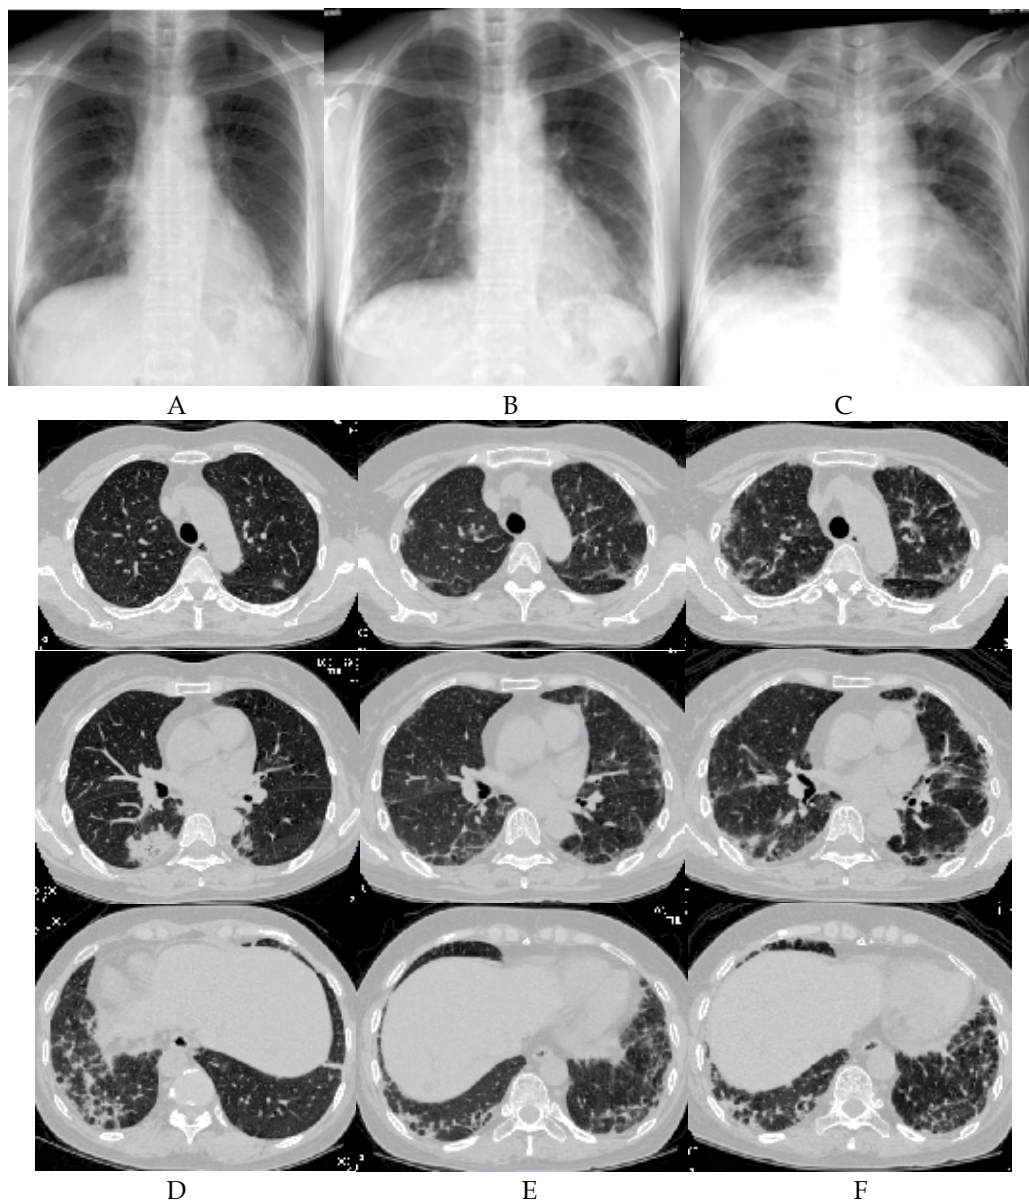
Chest radiographs and computed tomography of a case with interstitial lung disease associated with clinically amyopathic dermatomyositis resistant to treatment of corticosteroid and cyclosporin. Consolidation in lower lobes was improved by corticosteroid (A, B, D, E), but reticular and ground-glass opacities appeared and progressed in upper lobes to be fatal in spite of addition of cyclosporin (C, F).
